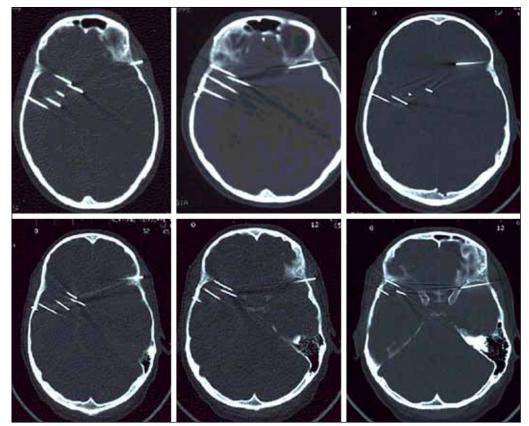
Axial CT images (bone window) of the head show multiple nails in the right and left temporal regions, and obliteration of the ventricular system.
